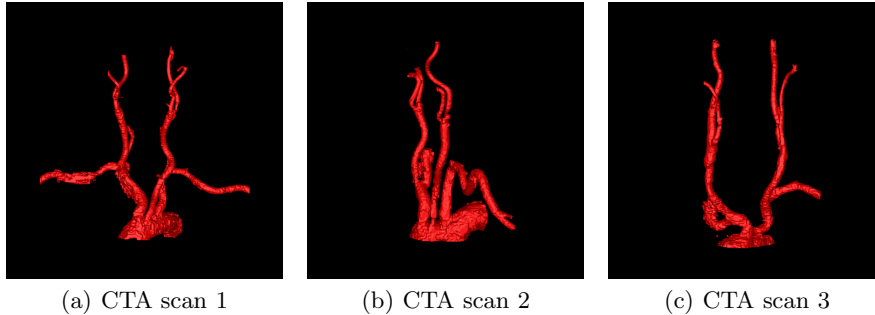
Spatial visualization of the surface vessel meshes constructed from three CTA scans after the nearly automatic refinement. 3D movies are available at: <http://www.cs.huji.ac.il/~freiman/vessels-cut>
